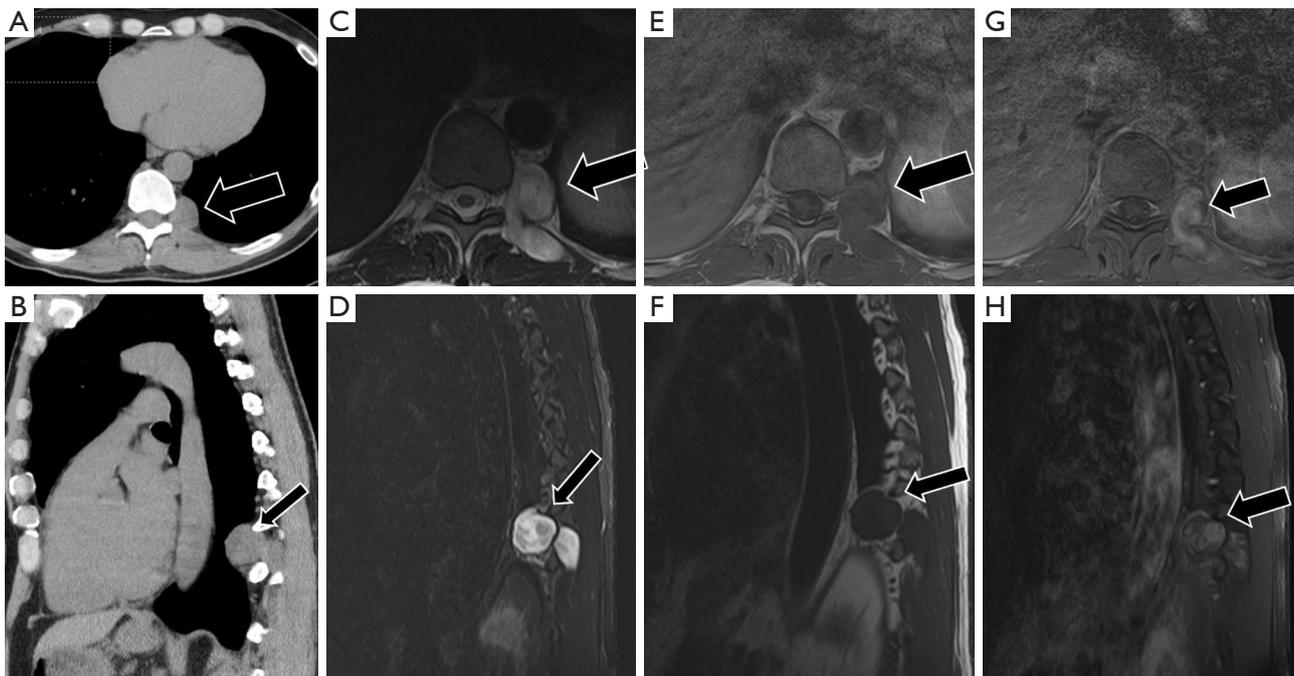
55-year-old male with cystic degeneration of a schwannoma. CT imaging demonstrates a soft-tissue density lesion (black arrow) arising in the paravertebral compartment (axial, A; sagittal, B). MRI imaging (black arrow) demonstrates a high T2 (axial, C; sagittal, D), intermediate T1 signal (axial, E; sagittal, F) lesion with extension to the posterior paraspinal musculature. Heterogeneous contrast enhancement is seen after the administration of gadolinium (axial, G; sagittal, H). Overall imaging findings compatible with cystic degeneration of a schwannoma. Also note the lack of direct communication with the thecal sac. CT, computed tomography; MRI, magnetic resonance imaging.
